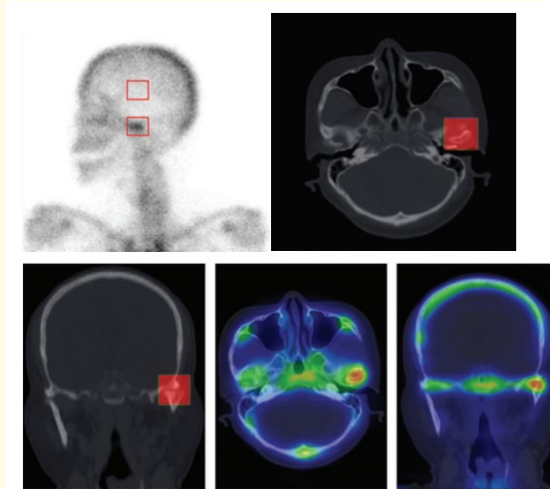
Different imaging techniques used for bone scintigraphy [19].
